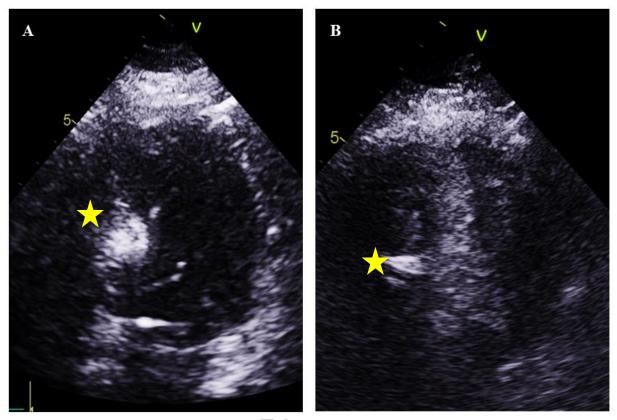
Still frames obtained from the apical four chamber transthoracic echocardiogram done during the alcohol septal ablation with (A) agitated saline and iodinated contrast mixture (B) Definity® ultrasound contrast agent injected through a microcatheter in the targeted septal perforator branch. The target area for alcohol ablation appears to be quite localized as shown in the focal area of opacification in the mid interventricular septum [asterisk] without right ventricular extension or involvement of the papillary muscle.
